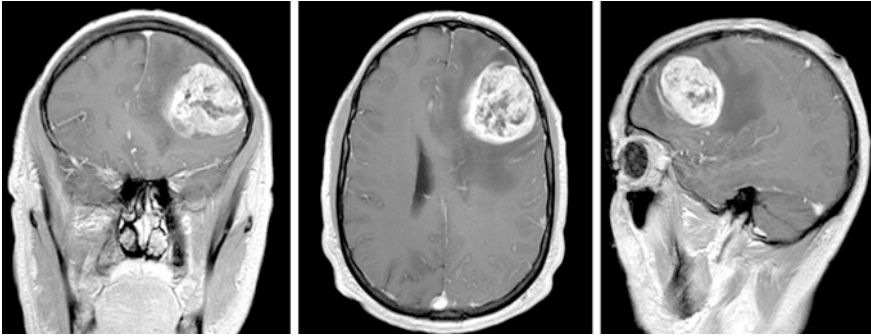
Example of patient with GBM. T1-weighted gadolinium enhanced magnetic resonance images demonstrating a left frontal tumor with mass effect. Pathology is consistent with glioblastoma multiforme
